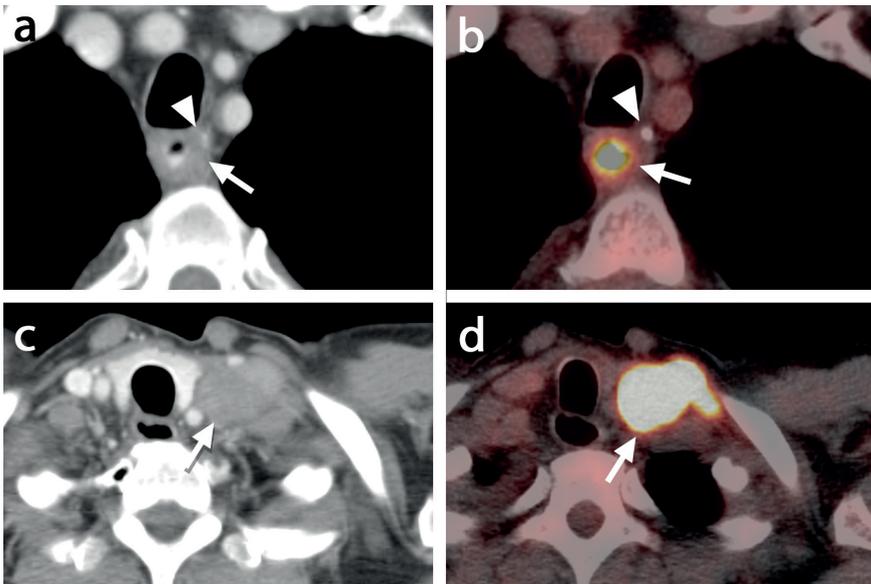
A 60 year-old man with a history of neoadjuvant chemoradiotherapy followed by transthoracic esophagectomy for a ypT2N1M0 adenocarcinoma of the distal third of the esophagus presented 6 months after surgery with dysphagia and a noted swelling in the cervical region. (a) Conventional CT was not able to clearly distinguish between normal postoperative changes or local recurrent disease at the cranial part of the gastric tube (*arrow*), but ^{18}F -FDG PET/CT showed intense ^{18}F -FDG uptake at the local site, highly suspected of local recurrence (*arrow*). Arrowheads in (a) and (b) indicate a surgical staple along the gastric tube. (c) CT revealed a large lymphadenopathy (*arrow*) in the left lower cervical region (level V), which in (d) showed high ^{18}F -FDG uptake on ^{18}F -FDG PET images. Cytologic examination of a fine needle aspiration of this node revealed recurrent metastatic adenocarcinoma.
